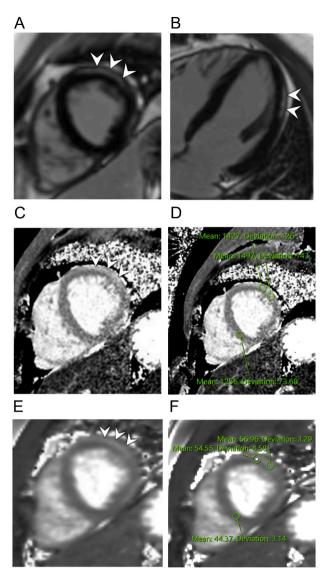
Magnetic Resonance Imaging of Case 1. Post contrast magnitude inversion recovery (MAG-IR) images in short axis (A) and four-chamber long axis (B) views show subepicardial enhancement in the anterolateral wall of the mid ventricle and apex (arrowheads). Native T1 map shows corresponding abnormality (arrowheads in C) with elevated values (D) in the anterolateral wall as compared to the interventricular septum. T2 mapping also showed abnormality in this region (arrows in E) with elevated values (F) when compared to the interventricular septum.
